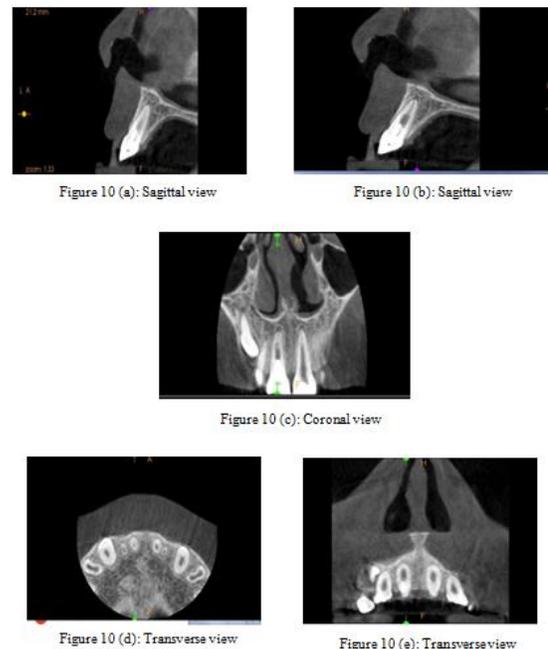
(a) to (e): CBCT sections of tooth #11 at 15-month follow-up showing an increase of root canal length and thickness with complete resolution of the periapical radiolucency and closure of the root apex.
